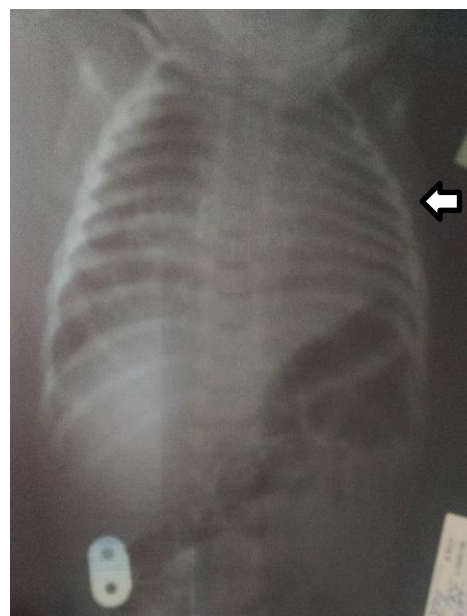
A 3-months-old male patient. Chest's X-ray
